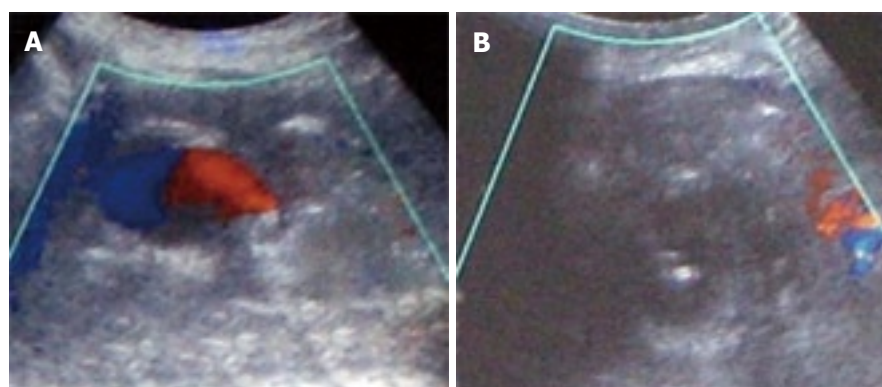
Ultrasound guided thrombin injection. A: Color doppler ultrasound. A small cavity persists with flow in the pseudoaneurysm; B: Needle inside the pseudoaneurysm immediately after the injection of thrombin showing the absence of flow (thrombosis).
